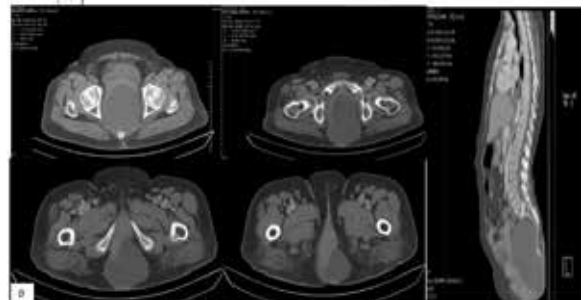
Axial and sagittal CT images of a 65yrs old asymptomatic patient showing a well defined homogeneous cystic density lesion in the retrorectal space.
